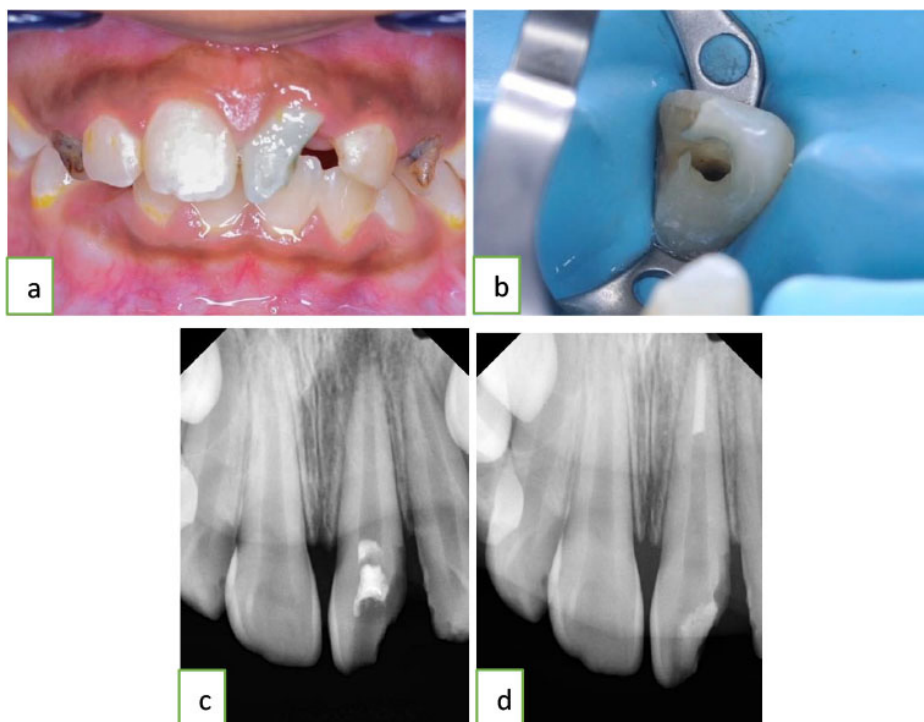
(a) and (b) Pre-operative #21, (c) Radiograph pre-operative, (d) MTA plug.
